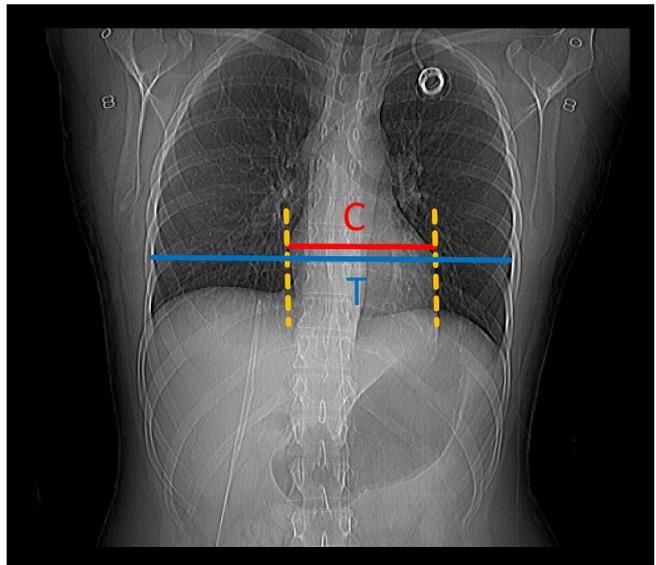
Frontal CT scout image depicting the method of measuring the maximum transverse cardiac diameter (C) and the transverse thoracic diameter (T)
